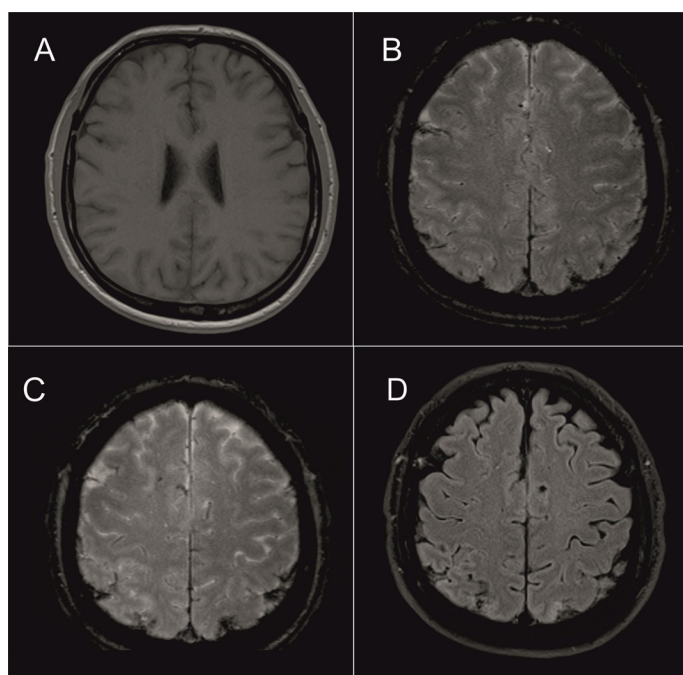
Axial of T1-weighted (A) and T2-weighted (B) images are essentially normal, but axial susceptibility-weighted imaging (SWI) (C) and fluid-attenuated inversion recovery (FLAIR) (D) sequences show few multiple microhemorrhage foci in the gray matter of both posterior parietal lobes, suggestive of subarachnoid hemorrhage (SAH)
